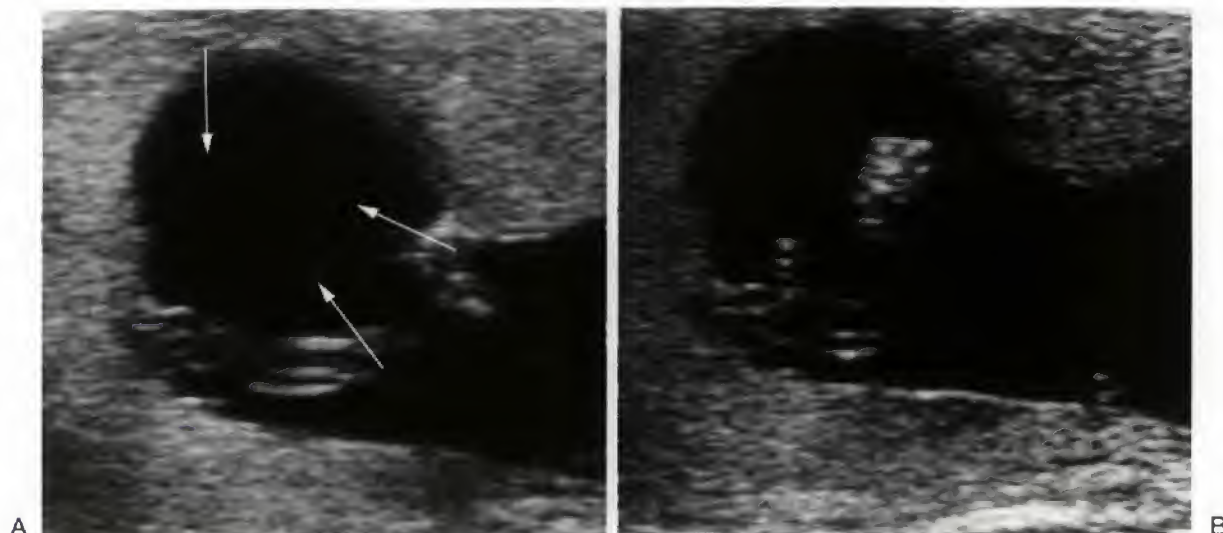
Side lobe (gradient) artifact can occur with even the most sophisticated ultrasound scanning equipment. In this case, a side lobe artifact is seen overlying the fetal head (*arrows*). The artifactual nature of these echoes can be confirmed by noting that these echoes are not confined to the head but extend beyond its confines. In addition, changing the scan plane orientation will show the region to be normal.
